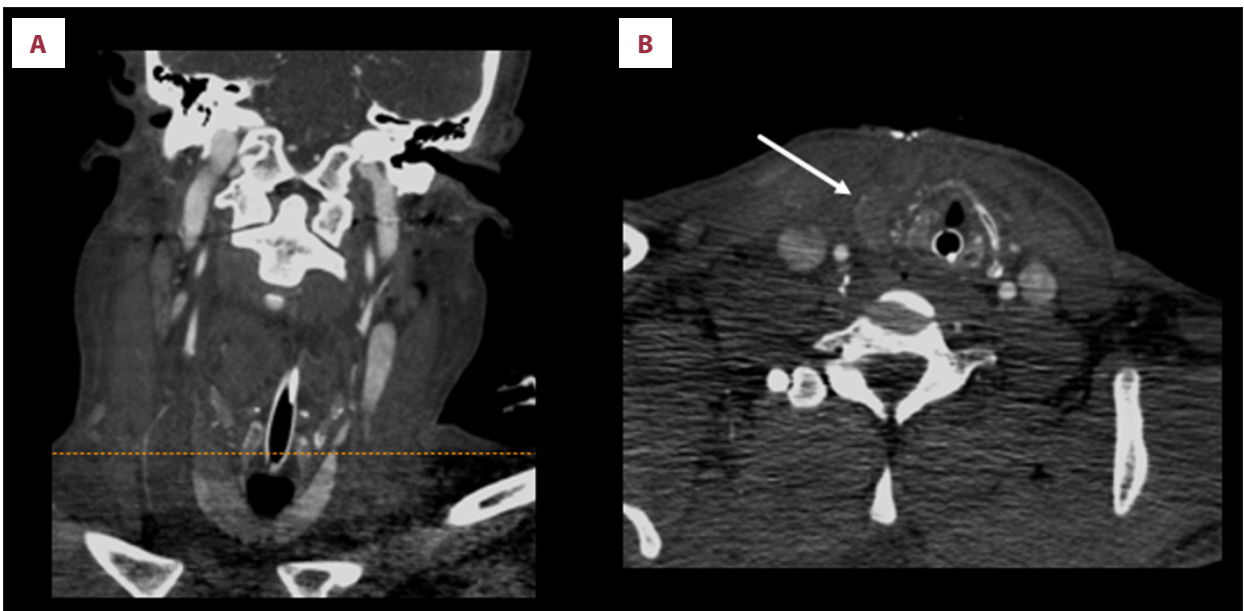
A coronal neck computed tomography angiogram shows enlargement/edema of the right thyroid lobe with asymmetric decreased parenchymal enhancement of the mid and superior aspects of the right thyroid lobe (arrow). Note the preserved parenchymal enhancement of the lower pole of the right thyroid lobe. An endotracheal tube is partially visible.
